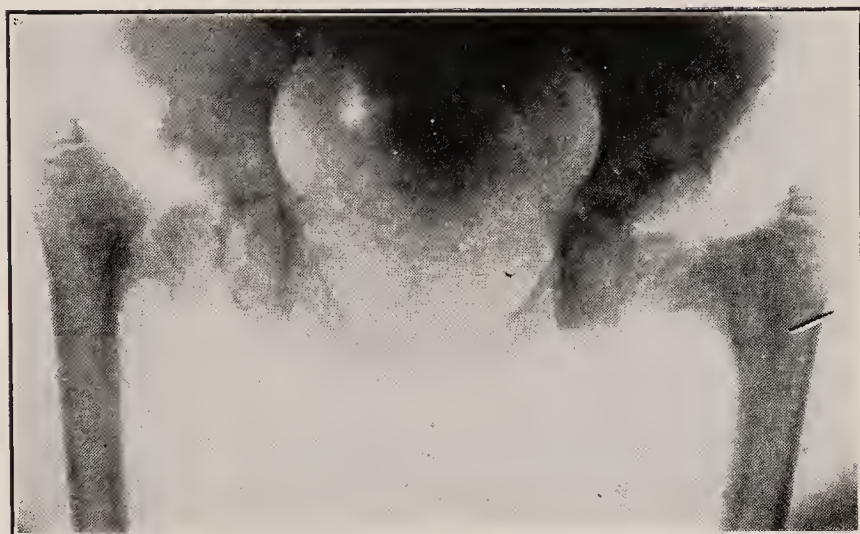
X-ray of congenital coxa vara. (The mother of this patient shows a similar deformity.)
